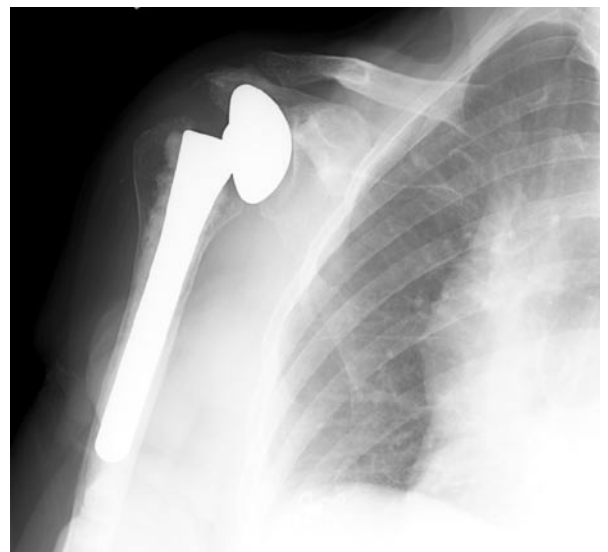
Preoperative radiograph shows well-fixed, cemented bipolar humeral prosthesis with medial and superior erosion.
